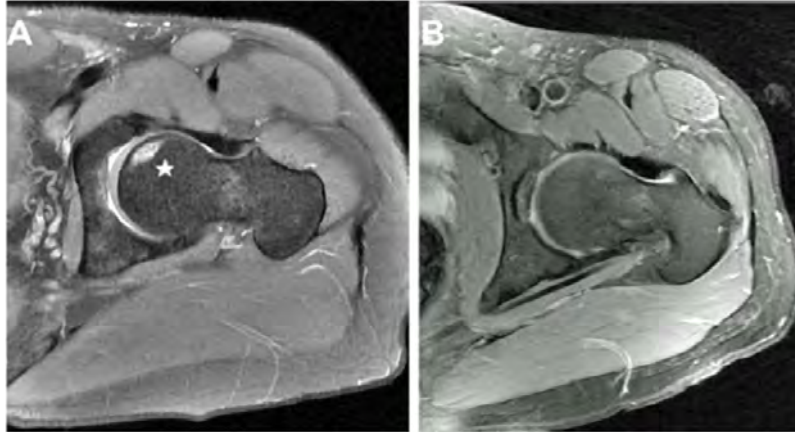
Preoperative MRI of a femoral head avascular necrosis lesion.
